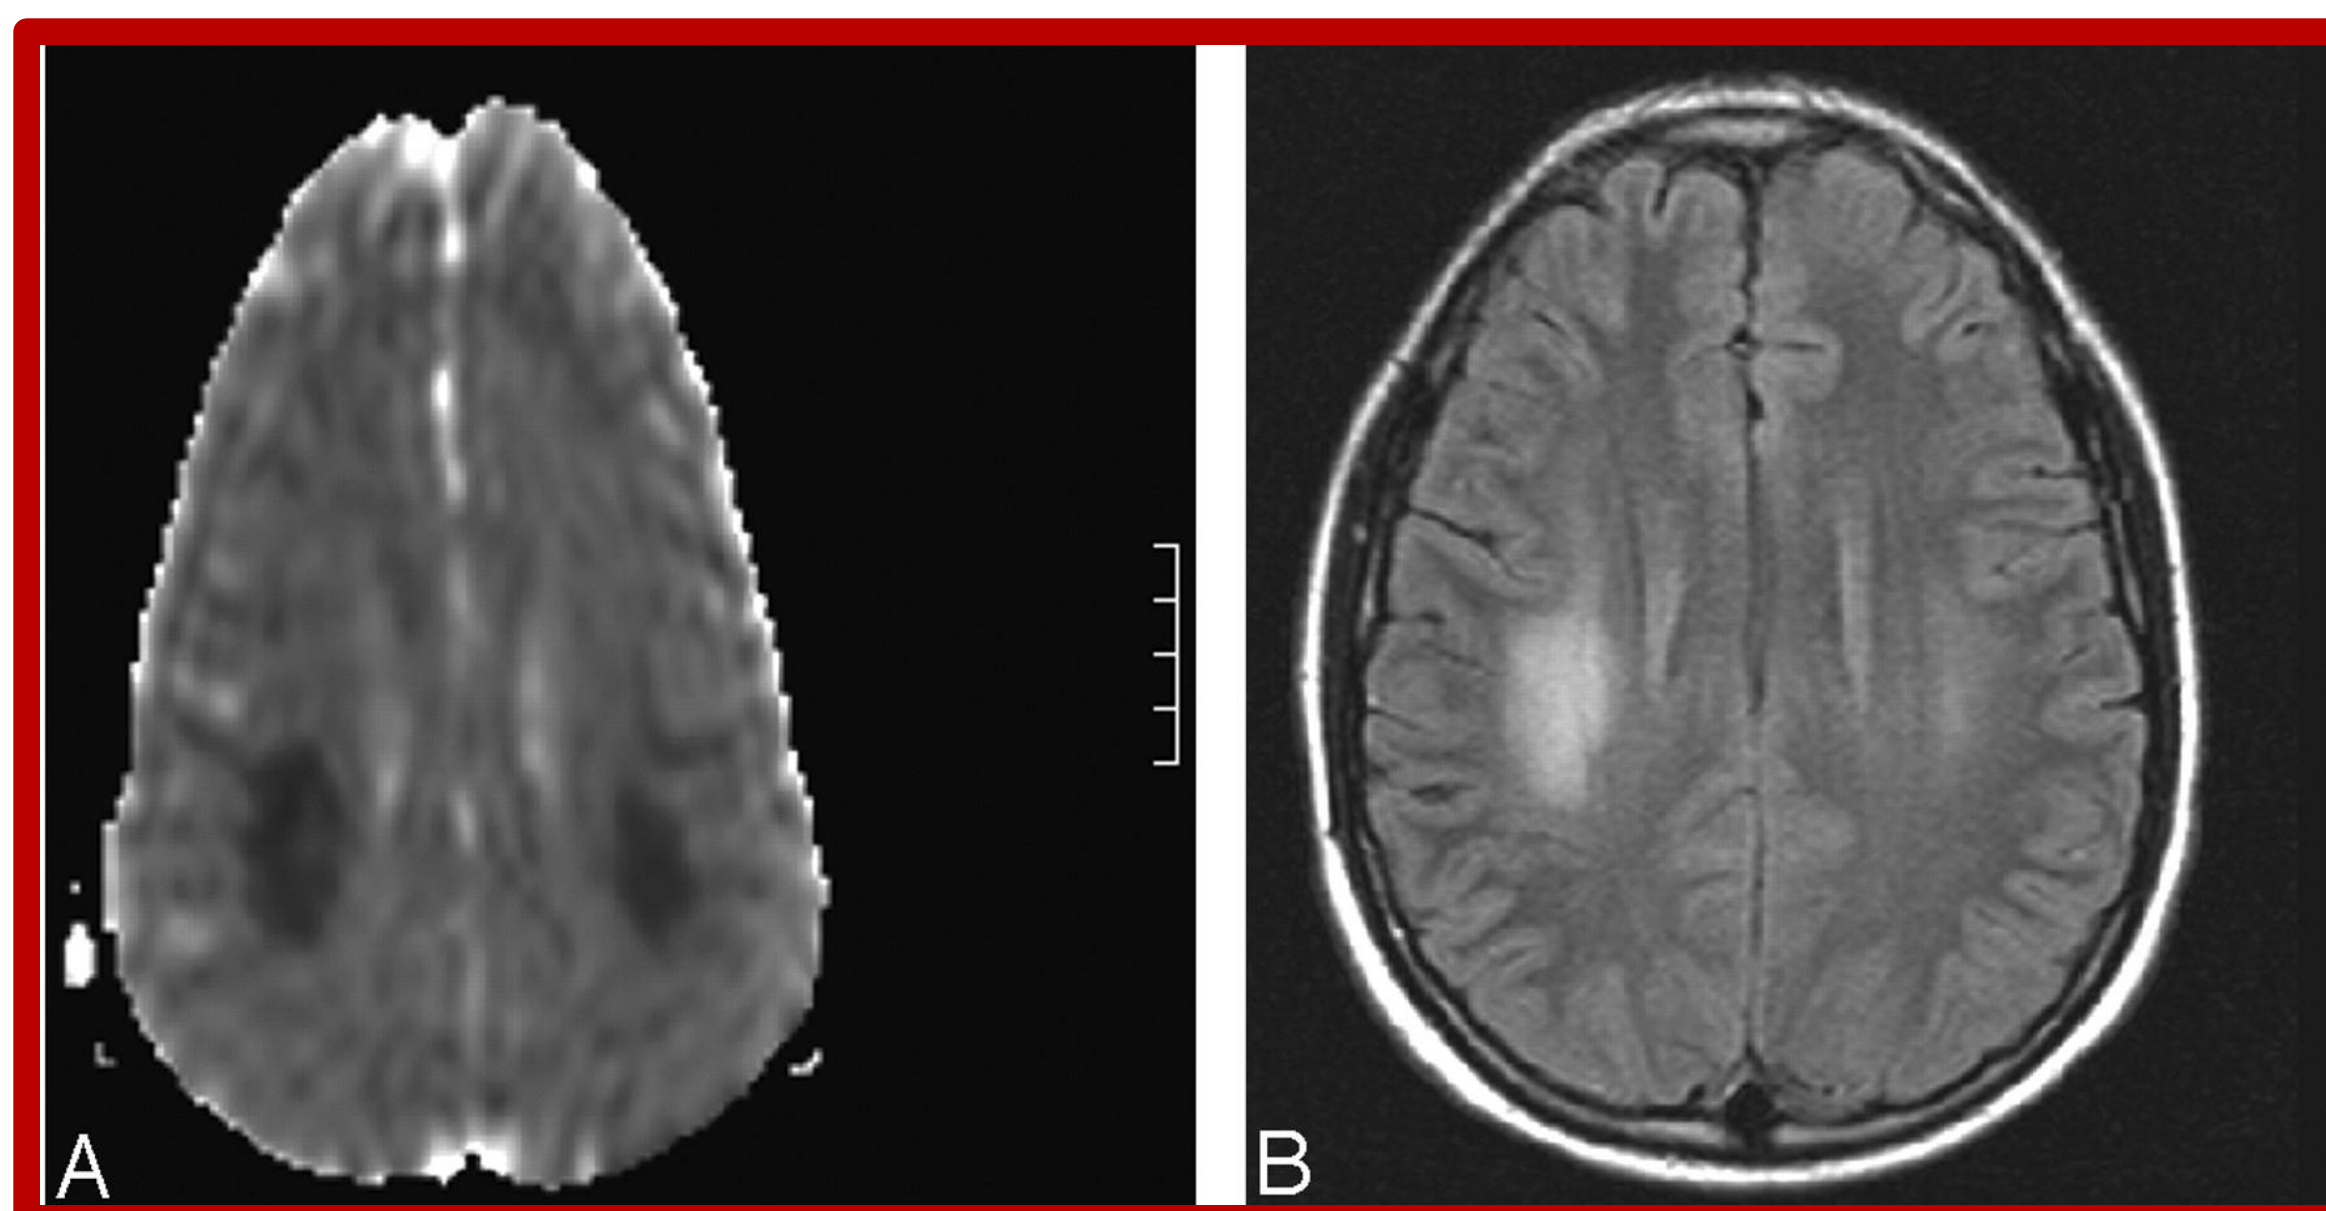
A pediatric patient presenting with nonfluent aphasia and left-sided hemiparesis/hemisensory loss. Image A is an axial ADC showing asymmetric areas of restricted diffusion in the centrum semiovale. The right-sided motor lesion correlated with left-side hemiparesis. Image B is an axial FLAIR imaged obtained eight weeks s/p neurotoxicity showing confluent areas of presumed demyelination in the right centrum semiovale. Neurological deficits had resolved.
